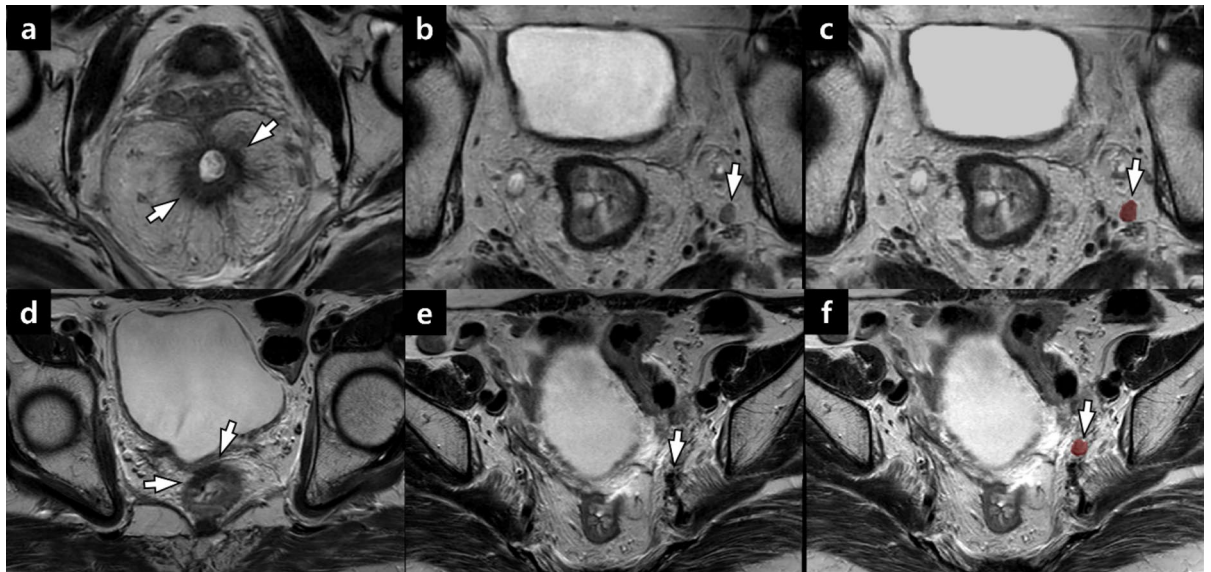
A 66-year-old man who underwent neoadjuvant chemoradiotherapy for rectal cancer. (a) Axial T2-weighted image demonstrates a circumferential wall thickening of the rectum (arrows), suggesting rectal cancer. (b) On an axial T2-weighted image, a 6 mm lymph node (LN) in short axis (arrow) with a well-defined margin and homogeneous signal intensity is seen at the left internal iliac chain. Both reviewers assigned a score of 3 (indeterminate) to this LN. (c) On a radiomics platform, the LN was semi-automatically segmented (arrow). According to the radiomics-based model, the calculated score was -0.37 , higher than the cutoff of -0.47 . The reviewers revised their scores from 3 to 4 (probably malignant) in the second interpretation session, considering the radiomics score. The patient underwent low anterior resection with bilateral lateral pelvic LN dissection, and the left internal iliac LN was pathologically confirmed as metastatic. The final pathologic staging was ypT3bN1. A 73-year-old woman who underwent neoadjuvant chemoradiotherapy for rectal cancer. (d) T2-weighted axial image shows a focal eccentric wall thickening with low signal intensity in the rectum (arrows), suggesting rectal cancer after neoadjuvant therapy. (e) On an axial T2-weighted image, a 6 mm LN in short axis (arrow) with homogeneous signal intensity and a well-defined margin is seen at the left internal iliac chain. Both reviewers assigned a score of 3 (indeterminate) to this LN. (f) On a radiomics platform, the LN was semi-automatically segmented (arrow). The radiomics score of this LN was -3.09 , below the cutoff of -0.47 . The reviewers revised the scores from 3 to 1 (definitely benign) in the second interpretation session, considering the radiomics score. The patient underwent low anterior resection with bilateral lateral pelvic LN dissection, and the left internal iliac LN was pathologically confirmed as benign. The final pathologic staging was ypT0N0.
